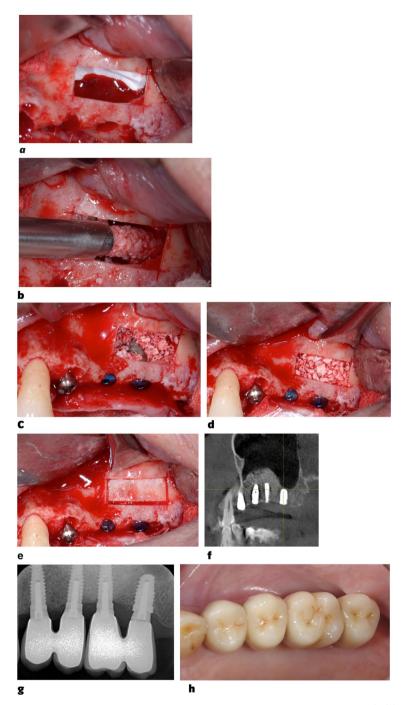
(a) a membrane is placed as a new superior wall to help contain the placed compressed bone graft; (b) The bone graft should be introduced into the sinus cavity under the most sterile conditions. Using a carrier to reduce the risk of graft infection; (c, d) If implant placement is planned during the same surgical phase, the graft should be applied to the anterior, posterior, and medial regions of the sinus, filling approximately two-thirds of the cavity. The implants are then placed, and the remaining graft material is added to complete the filling. (e) At the end of the grafting procedure a resorbable membrane could be placed over the antrostomy to prevent graft migration, reducing soft tissue ingrowth, and supporting bone formation. Another option is to reposition the bone lid removed during a lateral sinus lift procedure. This method aims to act as a natural barrier, encouraging osteogenesis, or new bone formation, by maintaining the autogenous bone's osteoconductive properties. (f) CBCT showing the post operative result; (g) Peri-apical radiographs at follow-up after implant loading; and (h) final restoration at follow-up. In clinical settings, there appears to be no significant difference in implant survival rates between the two techniques in the short term [65].
